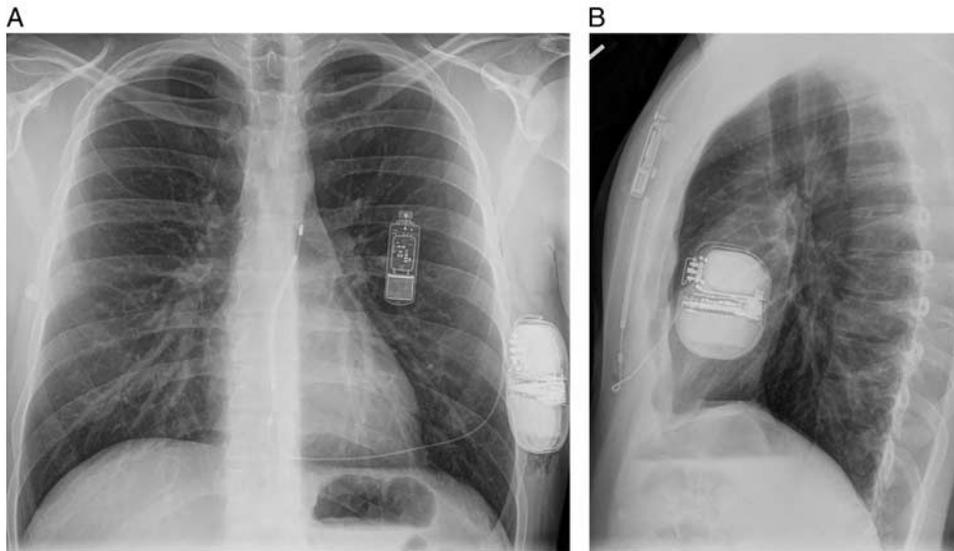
Subcutaneous parasternal ICD: frontal (A) and lateral (B) radiograph of subcutaneous ICD. Note the vertically oriented parasternal electrode and the horizontally oriented wire creating a perfect 45 degrees cardiac vector. In addition, an ILR is present, seen in the subcutaneous soft tissues on the lateral view.
